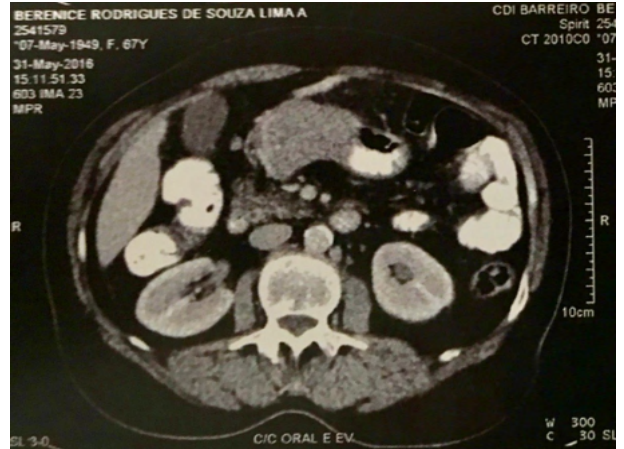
(top): CT section of the abdomen showing an expansive image in the stomach, suggestive of neoplasia.
